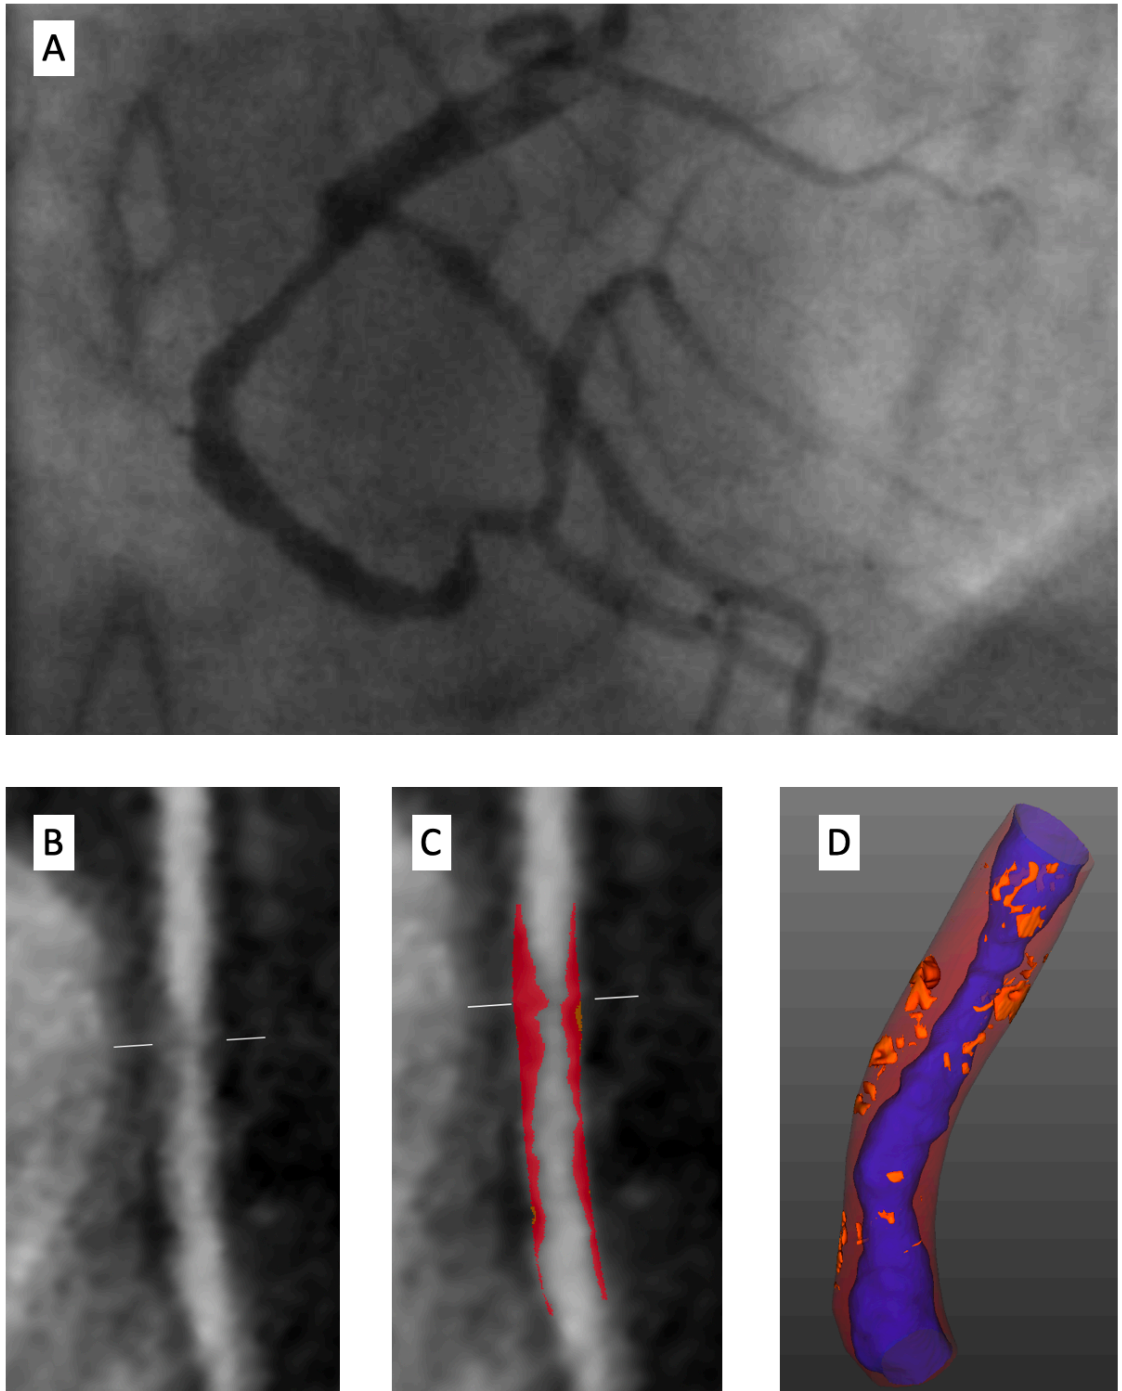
Plaque analysis example and invasive coronary angiogram; Images from a 46-year-old male presenting with chest pain and a peak high-sensitivity troponin of 8124 ng/L, diagnosed as a non-ST segment elevation myocardial infarction. (A) Invasive angiography demonstrates severe stenosis in the mid right coronary artery. CT curved planar reformation (B), quantitative plaque analysis (C) and 3D quantitative plaque analysis (D) demonstrated a high burden of low attenuation (in orange) and non-calcified plaque. Reproduced from Williams et al with permission.⁹⁸
